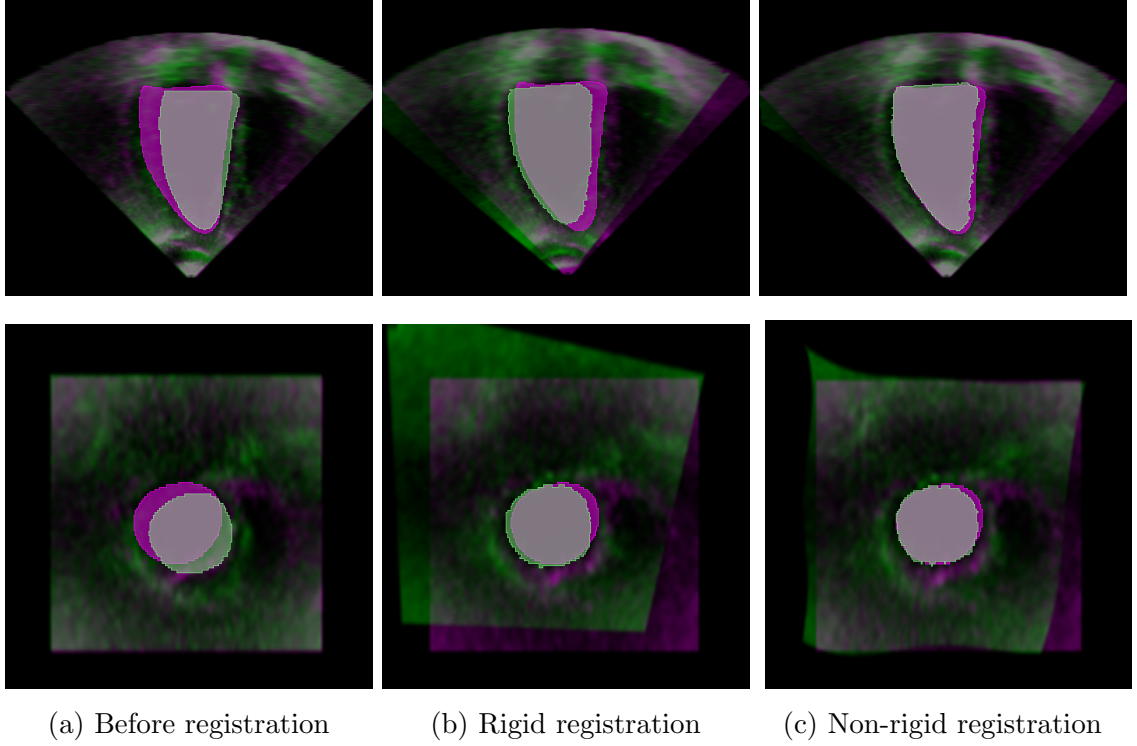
Example results for alignment of echo images with corresponding annotations. Original volumes, rigid and non-rigid registration results of an example pair of apical 3D echocardiography images in the long-axis (first row) and short-axis (bottom row) views. The fixed volume and the corresponding LV annotation are rendered in magenta, whereas the moving volume and annotation are rendered in green. The results indicate a significant alignment improvement for the apical and parasternal volumes and the corresponding LV annotations after image registration.
